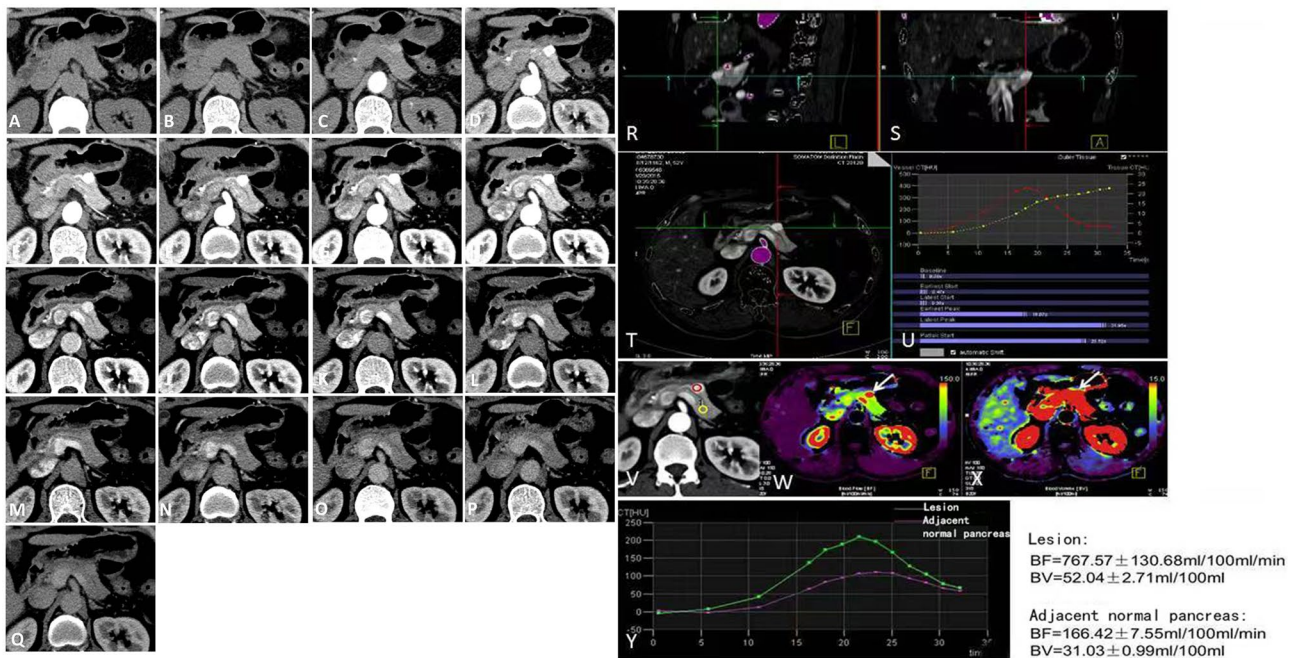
Representative case with "fast-in and fast-out" enhancement of lesions. The male was 52 years old with G1 functional pNETs in the body of pancreas. Perfusion map of the lesions in the body of pancreas at the same level was shown in (A-Q). (R-T) showed three-dimensional dual-source CT perfusion imaging in sagittal axis and coronal axis with the abdominal aorta used as the input artery (U). Region of interest was selected (V). The perfusion pseudo-color map of BF and BV was shown in (W-X). It could be seen that the lesion area was hyperperfused (arrow). Time density curves were shown in (Y), which showed that the enhancement pattern of the lesion was consistent with that of the adjacent normal pancreas, but the enhancement degree was higher than that of the normal pancreas
